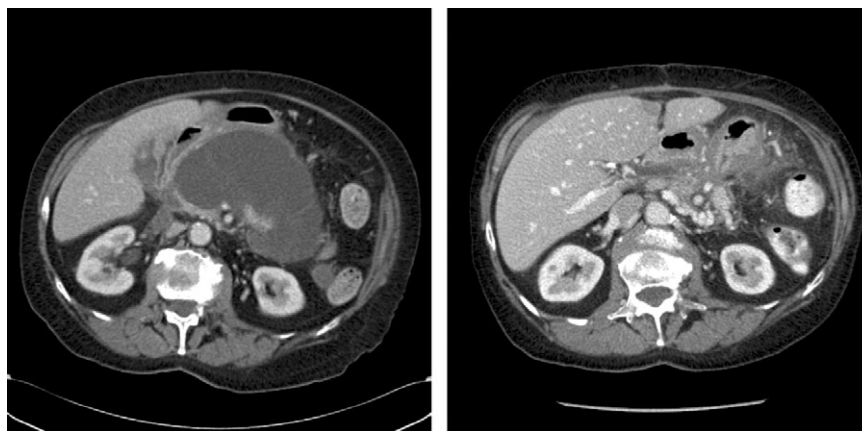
Pre-operative and post-operative computed tomography (CT) scan showing resolution of walled-off pancreatic necrosis (WOPN)
